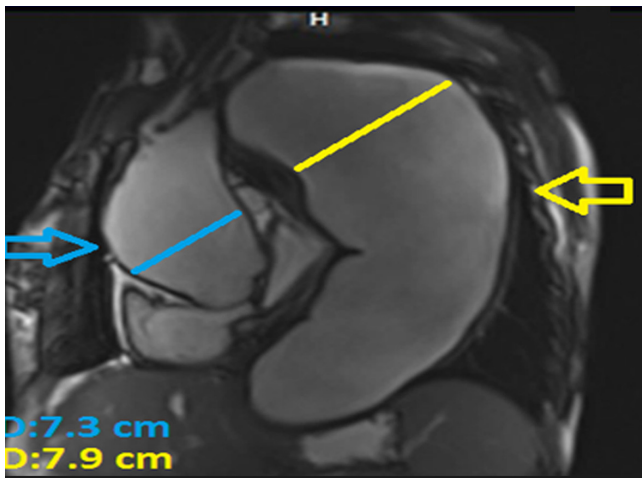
Sagittal view of cardiac magnetic resonance imaging, showing a massively dilated ascending aorta (blue arrow, 7.3 cm in diameter) and a large-sized descending aorta aneurysm (yellow arrow, 7.9 cm in diameter)
